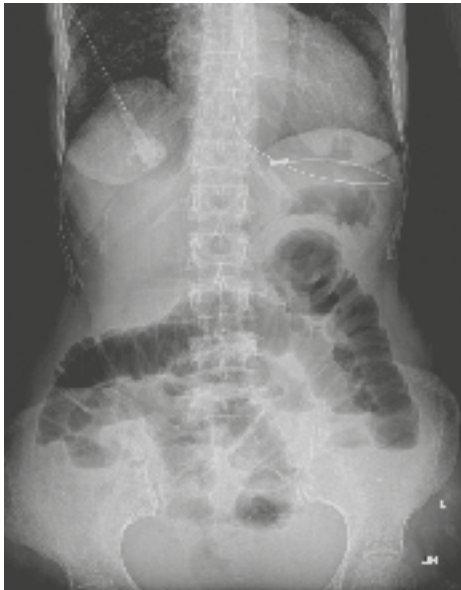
X-ray Abdomen Showing Intestinal Obstruction
